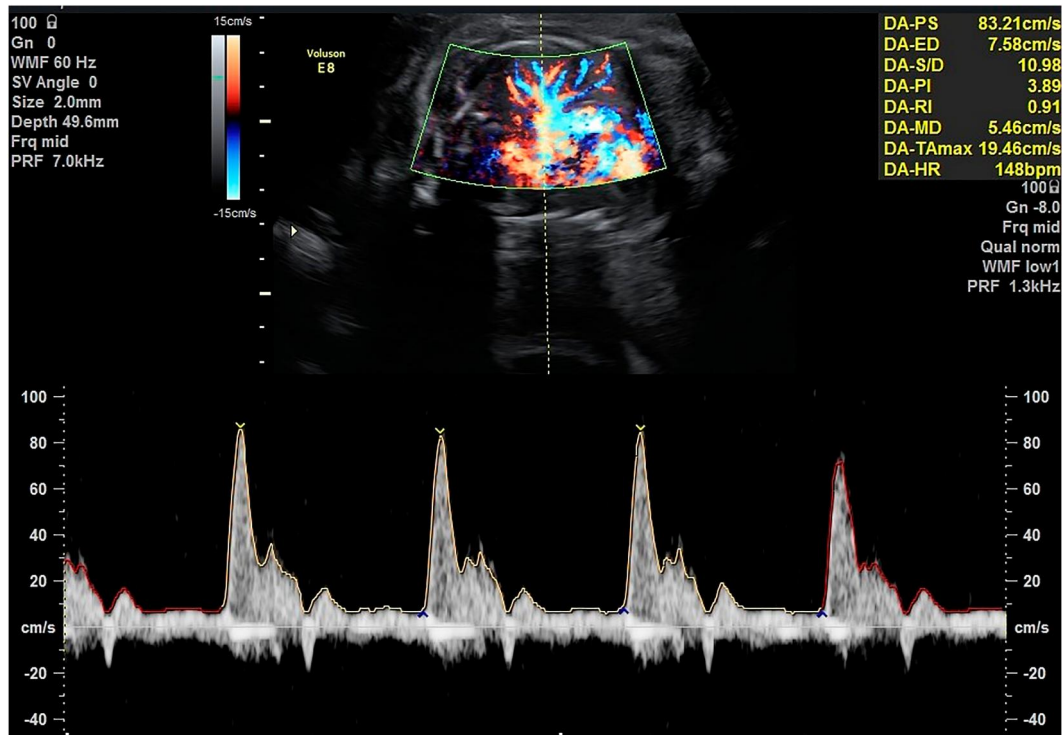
An example of the typical waveform in the most proximal branch of the pulmonary artery used for the assessment of the pulsatility index (PI), peak early-diastolic reverse flow, the waveform of the end-diastolic blood flow, acceleration time/ejection time ratio and time velocity integral. Ultrasound image from the Erasmus University Medical Center.
